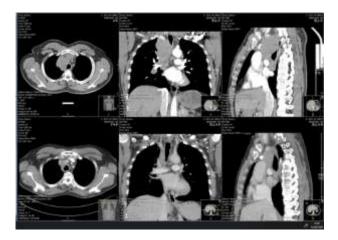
Imagiological response before and after thoracic RT. Above: thoracic CT June 2019 (3 months before RT); below: thoracic CT from April 2020 (6 months after RT).
